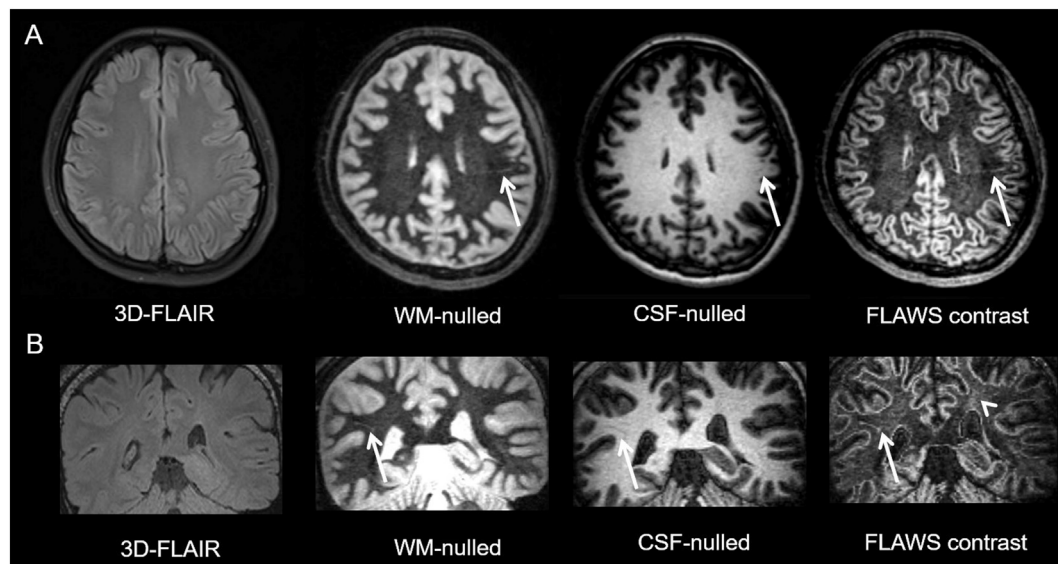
The thin-threadlike signal (arrow) in a 28-year-old female normal control (A) and a 16-year-old male FCD type II patient (B), respectively. The thin-threadlike signal is invisible on the FLAIR and visible on the FLAWS images. The arrow head points to the epileptogenic zone of the patient.
